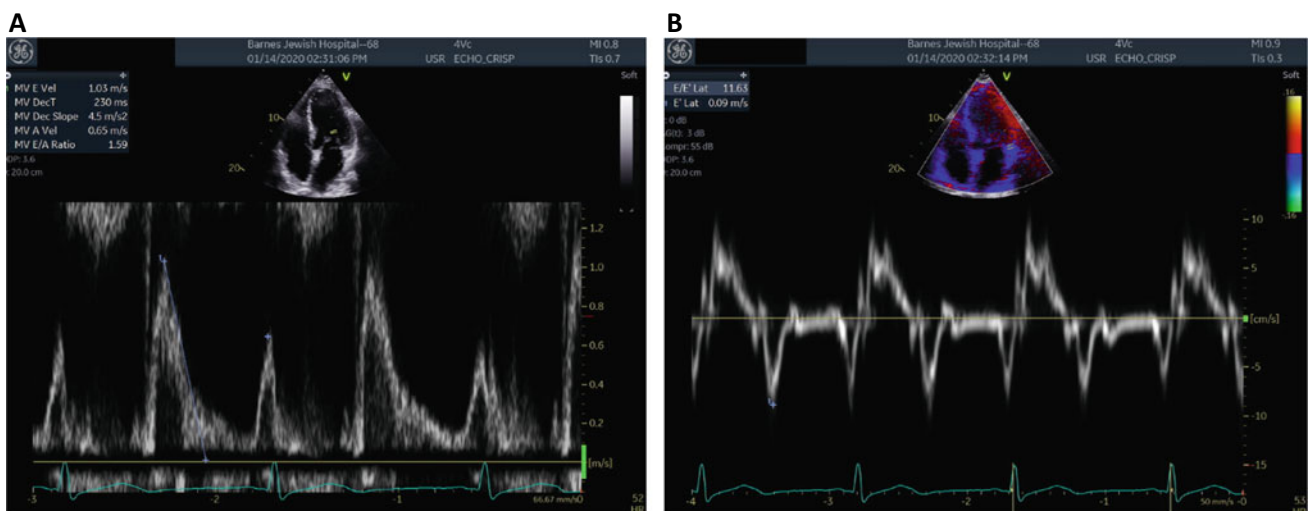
Normal diastolic filling parameters once sinus rhythm was restored. A Pulsed wave Doppler of the mitral valve showing E/A ratio of 1.6 and deceleration time of 230 ms. B Tissue Doppler of the mitral annulus showing E' lateral of 9 cm/sec with E/E' ratio of 1.2
